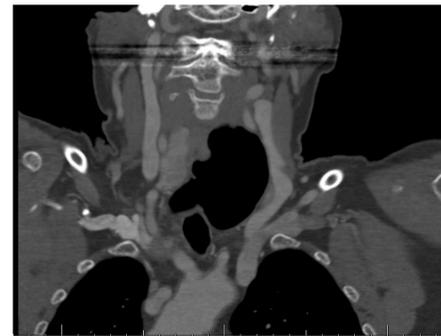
Coronal CT demonstrating left esophageal dilation
